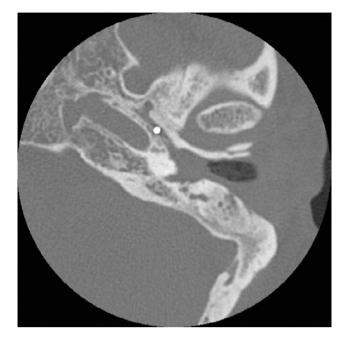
Computed tomography image showing the foreign body displaced deeper into the eustachian tube.
